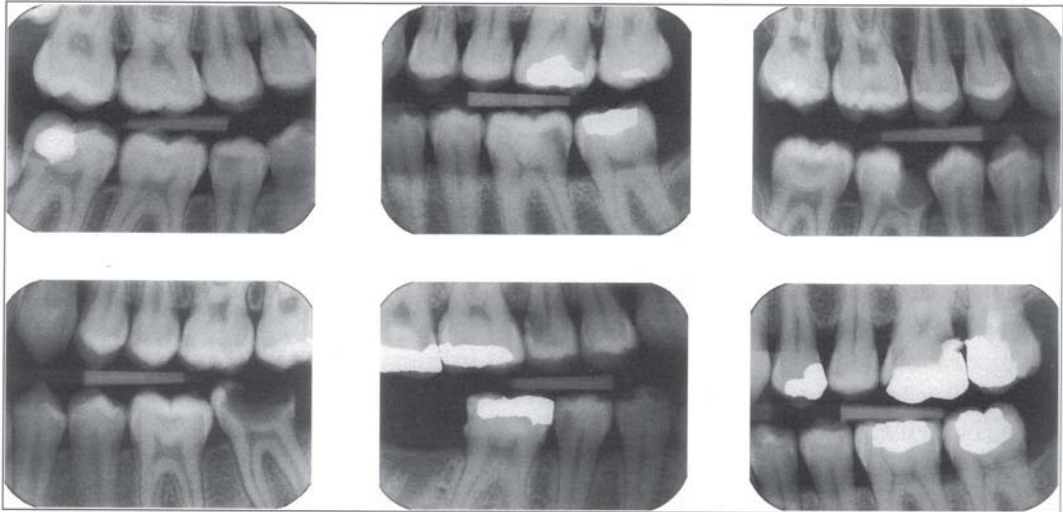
Bitewing radiographic image of different sized caries lesions in proximal and occlusal caries. (Adapted from Whaites, In Minimally Invasive Dentistry: The management of caries, Eds. Wilson NHF. Quintessence Publ. Co, Ltd, London, et al., 2007.
